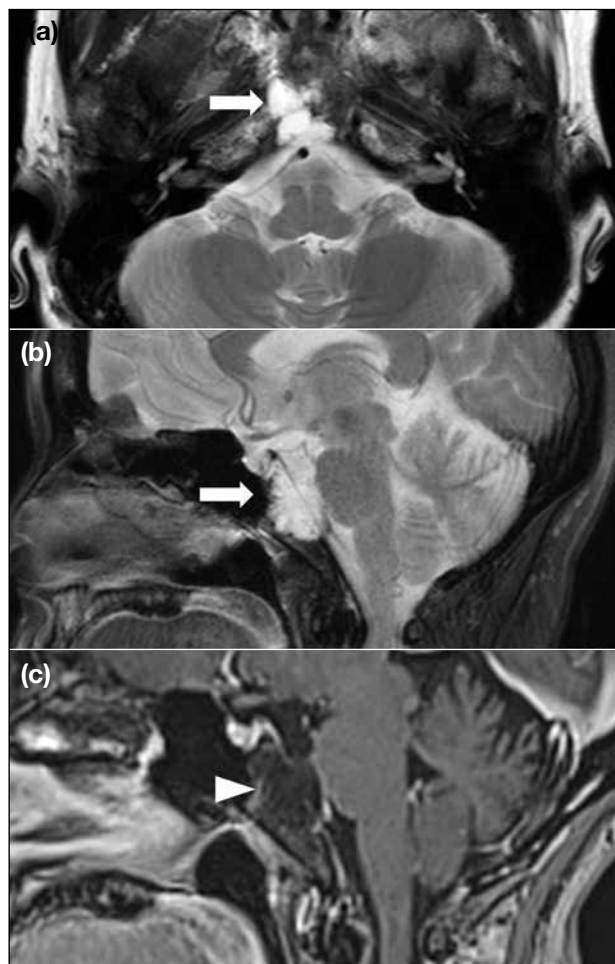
Magnetic resonance image of the brain. A homogenous retroclival lesion demonstrated homogenous hyperintense signal on T2-weighted image (arrow) in (a) an axial view and (b) a sagittal view. (c) This lesion showing hypointense signal on T1-weighted image without enhancement in post-gadolinium image (arrowhead).
